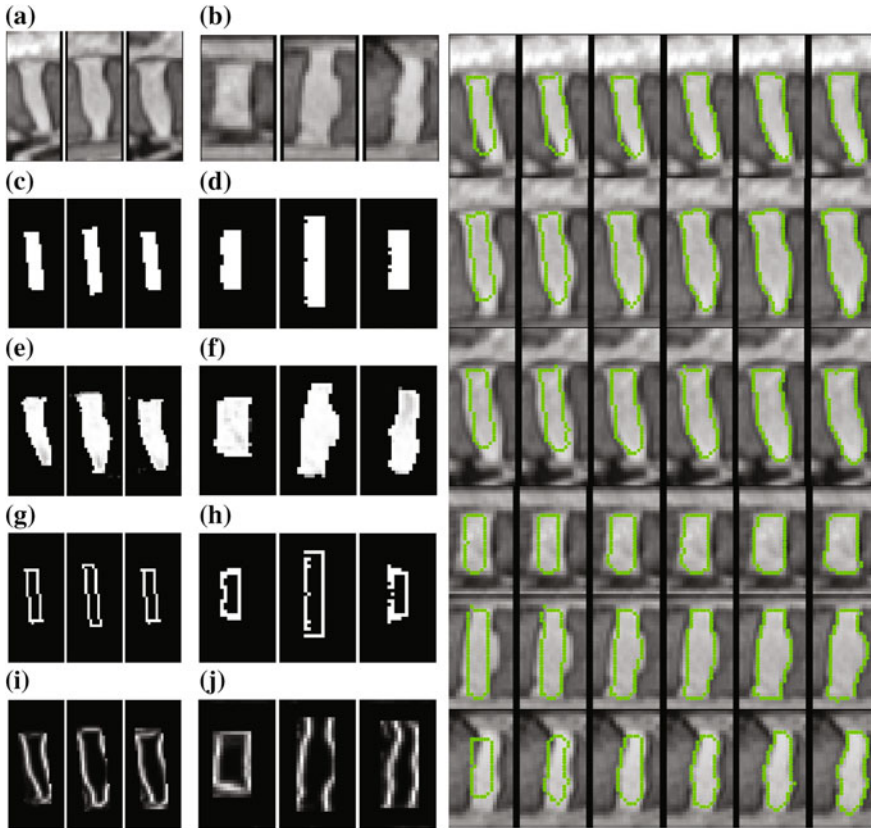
3D IVD segmentation by multi-kernel LDDMM registration *Left side*: The data used in diffeomorphic registration based 3D lumbar disc segmentation. In the target images, the bone tissue regions are extracted using the spine column model. a–b: 3 sagittal/coronal slices of the candidate disc region (disc L4-L5 in Fig. 2); c–d: the intensity disc template in 3 sagittal/coronal slices; e–f: intensity information extracted from MRI data sets in 3 sagittal/coronal slices; g–h: the edge disc template in 3 sagittal/coronal slices; i–j:edge information computed from MRI data sets in 3 sagittal/coronal slices; *Right side*: The time-dependent deformation of the disc template during the multi-kernel diffeomorphic registration for a L4-L5 disc segmentation. *left to right*: the deformations of the template at 6 time slots $t = 0, 0.2, 0.4, 0.6, 0.8, 1$. $t = 0$ means the initial template and $t = 1$ gives the final registration results; from *top row to bottom row*: the evolution of the template visualized in 6 different slices
